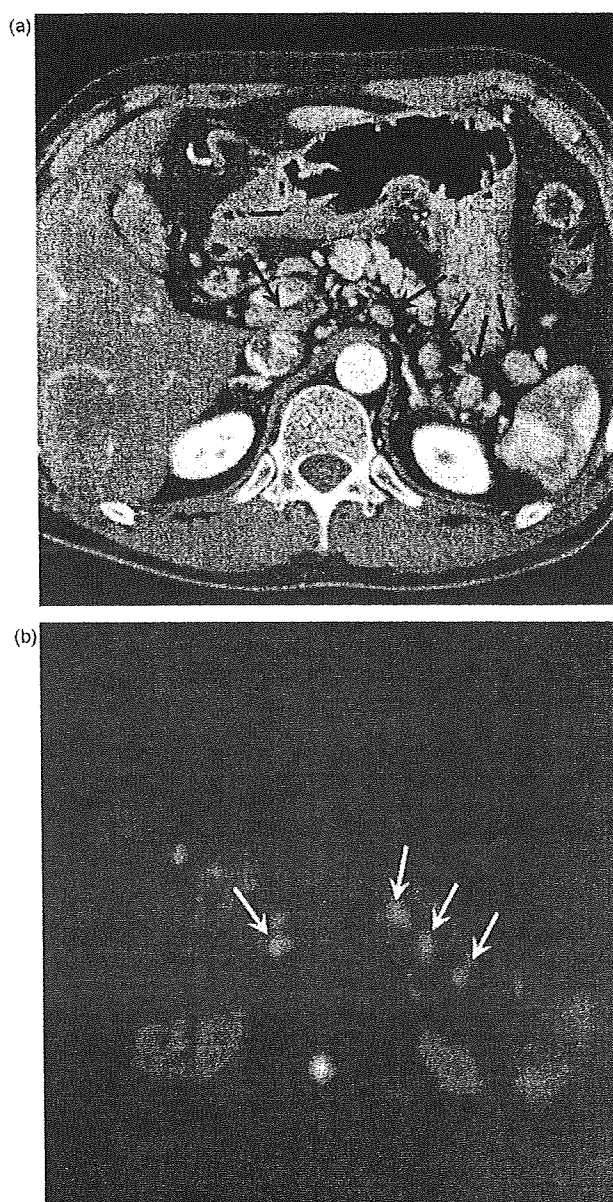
Peri-pancreatic and para-aortic lymphadenopathy in a 55-year-old man. (a) Contrast-enhanced CT shows multiple peri-pancreatic lymphadenopathy (arrows). (b) On diffusion-weighted images, these lesions are detected as high intensity signals (white arrows).
